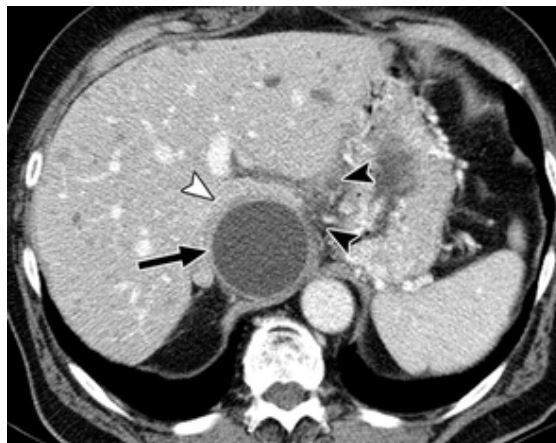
Pseudocyst related to prior episode of pancreatitis in 45-year-old man. Axial contrast-enhanced CT image of liver shows round low-attenuation lesion centered in subcapsular region of caudate lobe (arrow). Mass has thick peripheral rim (white arrowhead) and adjacent
